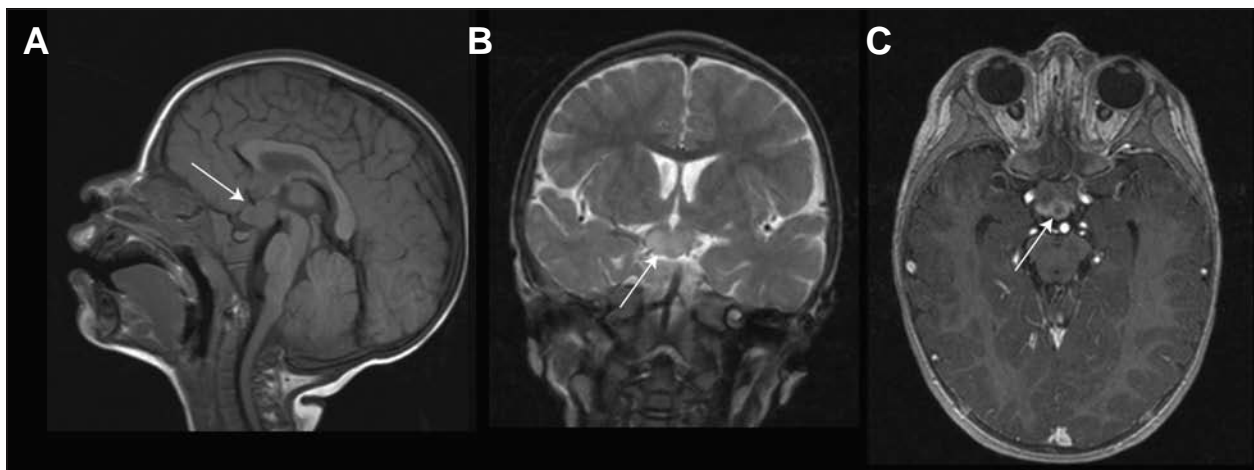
A) Sagittal T1 weighted image through the corpus callosum revealing a suprasellar mass involving the hypothalamus, mammillary bodies and superior pituitary stalk isointense to gray matter (arrow) B) Coronal T2 weighted image revealing a hyperintense chiasmal mass C) Axial contrast enhanced MP-RAGE sequence (Magnetization Prepared Rapid Acquisition Gradient Echo, T1-weighted) revealing a heterogeneously enhancing mass of the optic chiasm.
